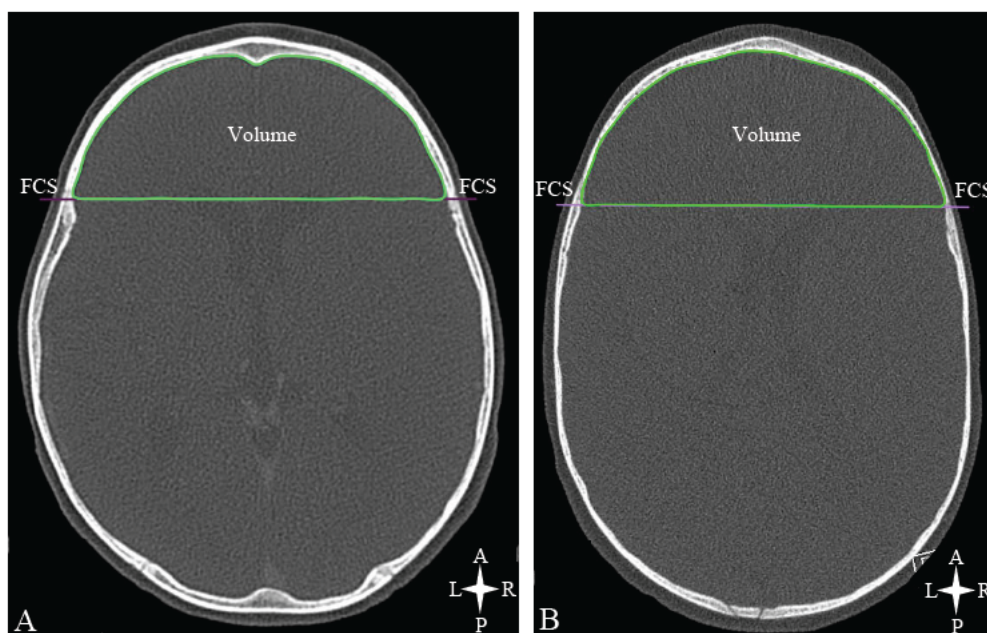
Volume measurement of the ACF on an axial CT scan of a normal patient (A) and trigonocephaly patient (B). Key: FCS – fused coronal suture
